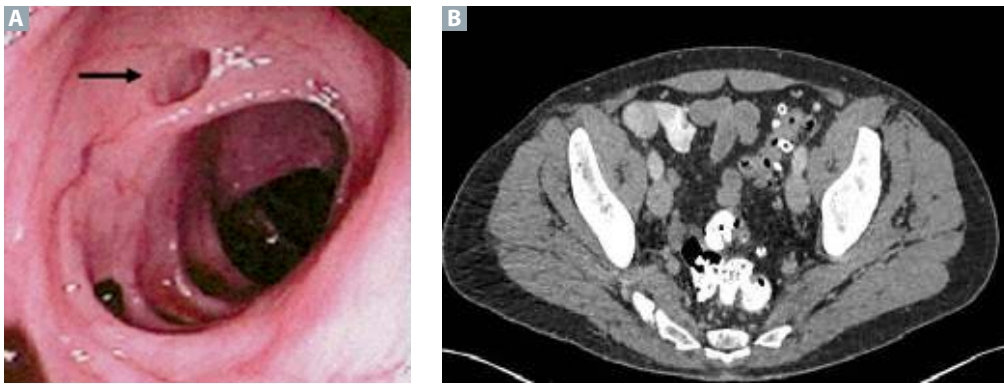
(A) An endoscopic view of diverticulosis. (B) An axial CT slice visualizing diverticulosis. (Image A adapted with permission from USMLE-Rx.com. Image B adapted with permission from Sartelli M, Moore FA, Ansaloni L, et al. A proposal for a CT driven classification of left colon acute diverticulitis. *World J Emerg Surg.* 2015;10:3. <https://doi.org/10.1186/1749-7922-10-3>.)
